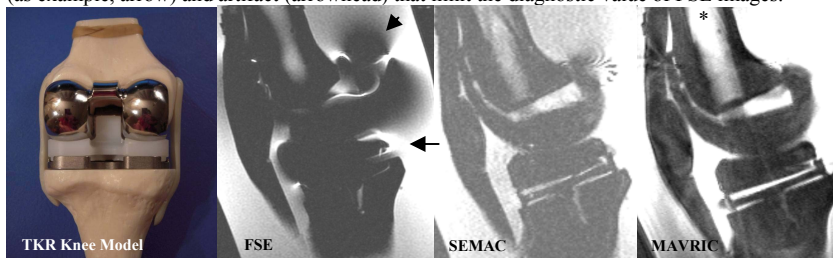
(Left) Posterior view of TKR model of the knee, consisting of plastic bones filled with oil (*) and fitted to metal components. (Right) Sagittal MR images of the TKR knee model. FSE images had severe metal-induced distortion (arrow) and artifact (arrowhead).
